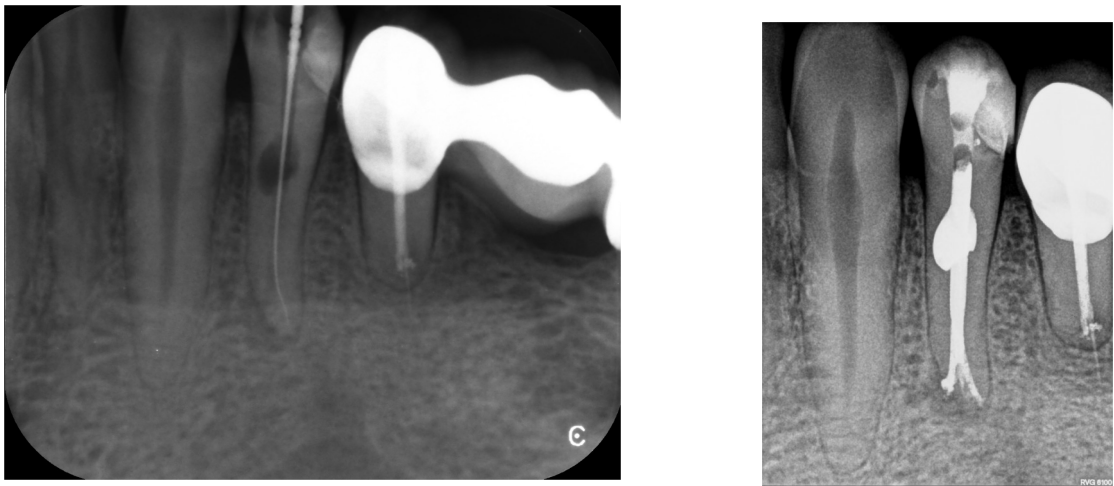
A) Working length determination & B) Obturation radiography
